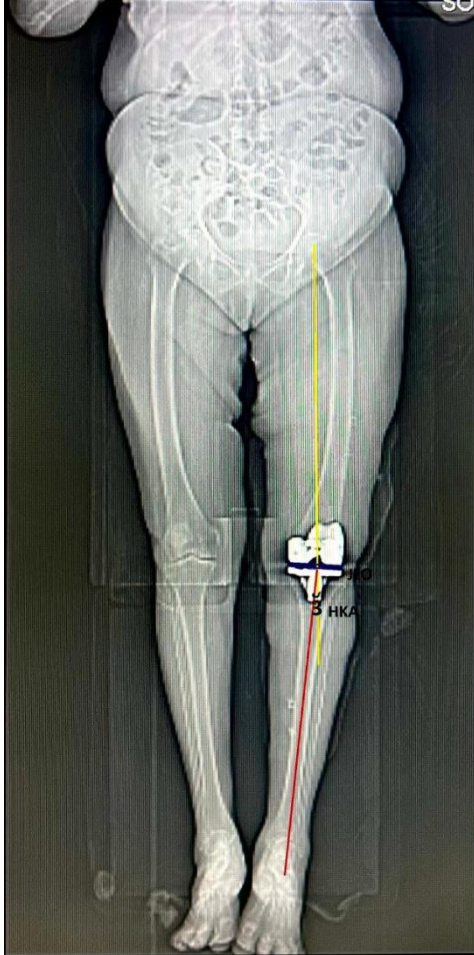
CT Topogram Picture depicting the HKA angle and JLO angle in a post operated Robotic Total Knee Replacement for a severe varus Left knee joint.
